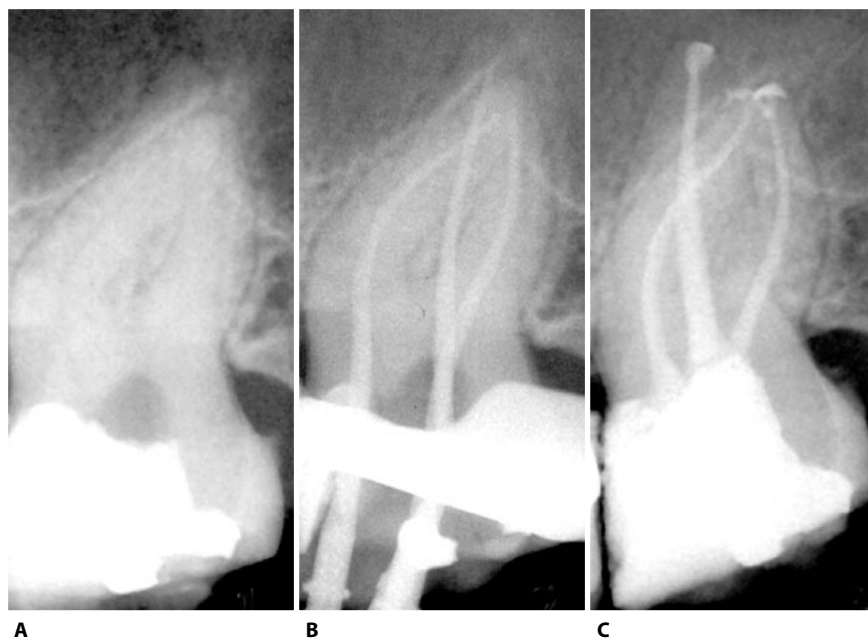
A. Endodontic treatment of an upper left second molar with very curved roots. B. Working length and selection of Thermafil obturators using plastic carriers as verifiers. C. Post operative radiograph.
